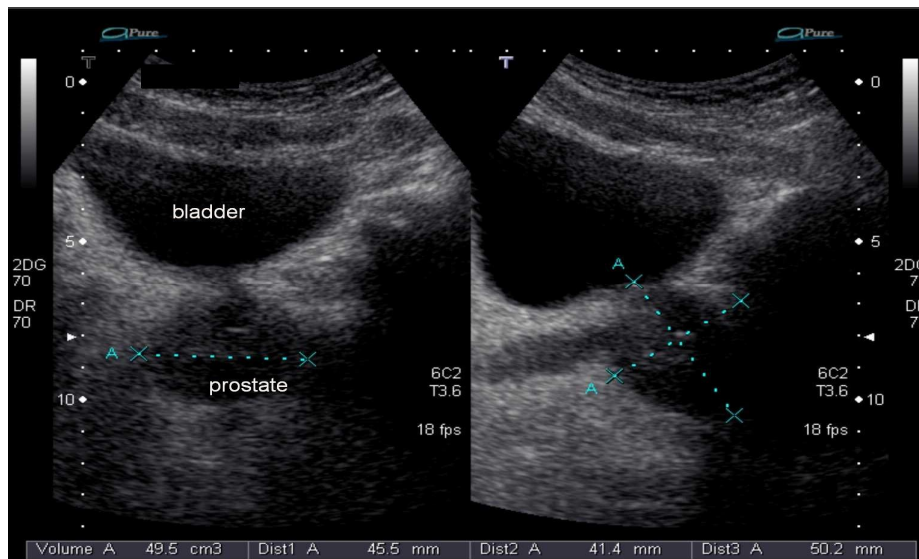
Shows sonographic appearance of prostatitis..(Viable ultra sonnd CD.ROM)
